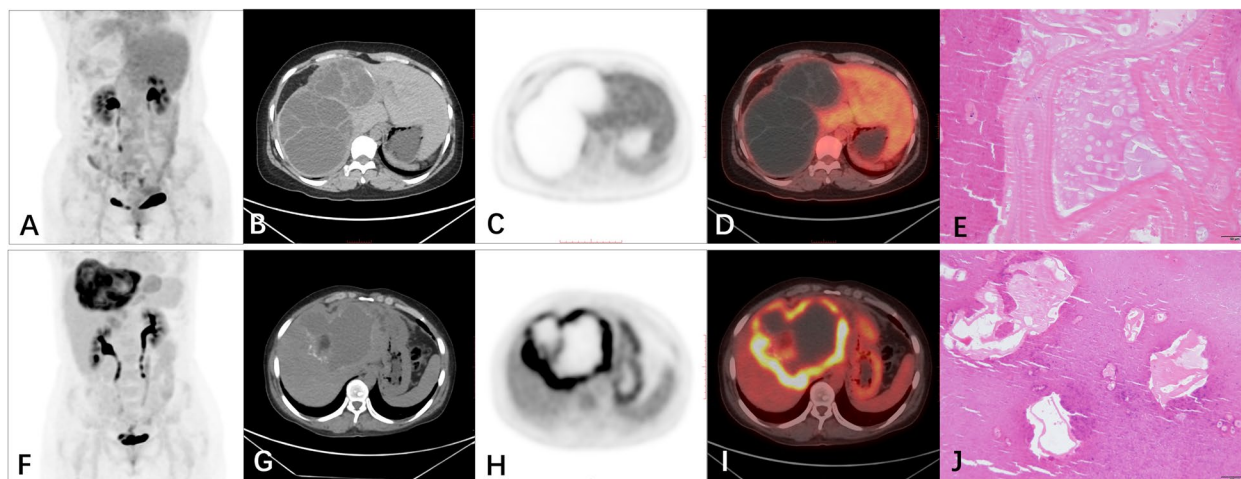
A-E Representative ¹⁸F-FDG PET/CT images of one patient with HCE (A maximum intensity projection (MIP), B CT, C PET, D fusion, E pathology). F, J Representative ¹⁸F-FDG PET/CT images of one patient with HAE (F MIP, G CT, H PET, I fusion, J pathology)
